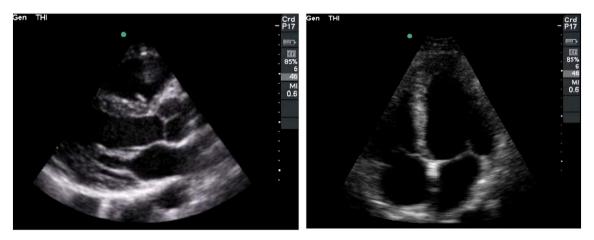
Bedside trans thoracic echocardiography ruling out any pericardial effusion or structural cardiac abnormality.
